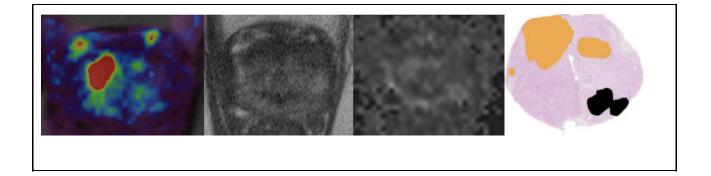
Dataset case of (left to right) axial DCE, axial T2, axial DWI and axially sliced wholemount radical prostatectomy with index tumour marked orange. The left AFMS tumour is subtle on T2 and DWI. There is early contrast enhancement on the DCE map.
